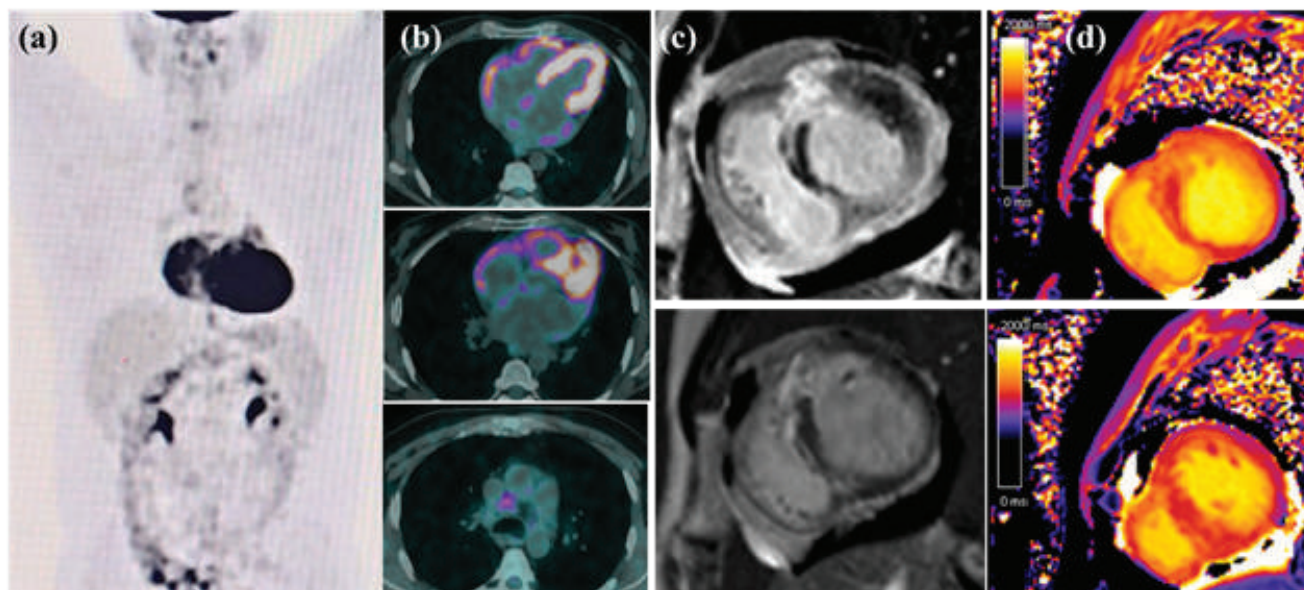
$^{18}\text{F}$ -FDG PET-CT and Cardiac MRI findings in the same patient. (a) Fused PET-CT images demonstrate diffuse, heterogeneous FDG uptake in the left ventricular myocardium, consistent with active myocardial inflammation. (b) CT images show marked pericardial effusion.
